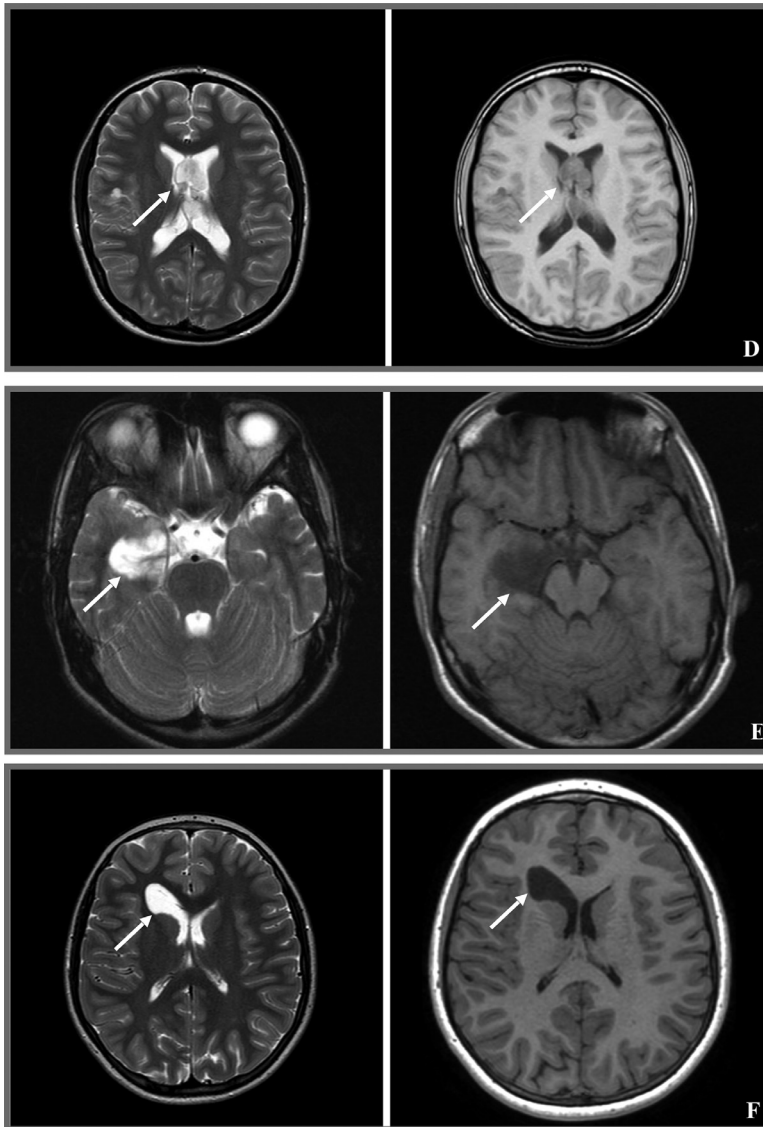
Neuroradiologic features of MGTs reported in this series. All cases displayed a lesion with hyperintense signal in T2-weighted images and with hypointense signal in T1-weighted images, without contrast enhancement. (A: MGT#1; B: MGT#2; C: MGT#3; D: MGT#4; E: MGT#5; F: MGT#6).
